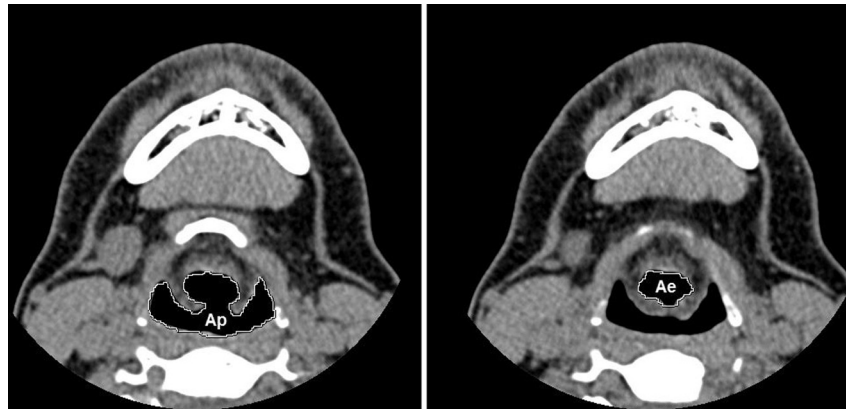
Areas (mm^2) measured in CT transversal images: the inlet to the lower pharynx (Ap) and the outlet of the epilaryngeal tube (Ae).
